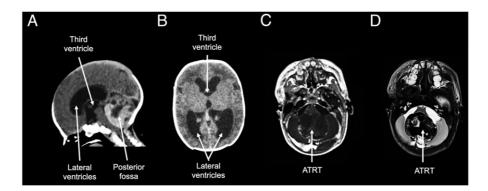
Imaging of a 1-day-old infant presenting with irritability and macrocephaly. Sagittal computed tomographic scan (A) shows a posterior fossa lesion with accompanying enlarged ventricles, which are confirmed on the axial view (B). Then, a T1-weighted magnetic resonance image, axial view with contrast (C), shows a non-contrast-enhancing heterogenous lesion in the posterior fossa causing obstruction by mass effect, which is then reconfirmed on axial T2-weighted imaging (D). Such findings are compatible with obstructive hydrocephalus, which in this case required surgical resection for definitive treatment. Final pathology was atypical teratoid/rhabdoid tumor (ATRT).
